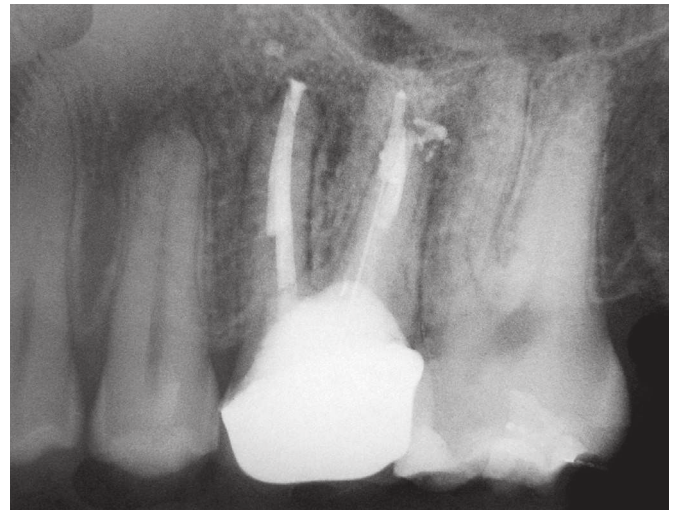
Control radiograph 36 months after treatment onset. Note periapical bone repair.
